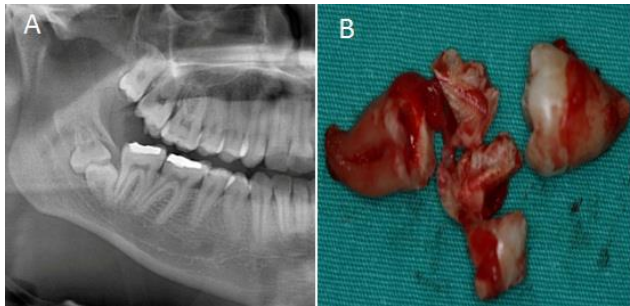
A. Panoramic radiograph showing impacted right third and fourth mandible molars with occlusal surfaces contacting each other in a single follicular space. B. Extracted kissing molars.
